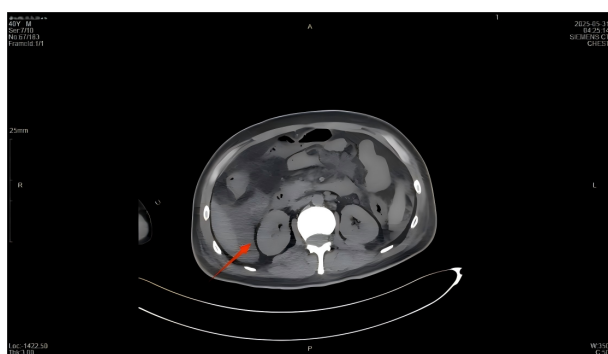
Abdominal CT display moderate peritoneal effusion
